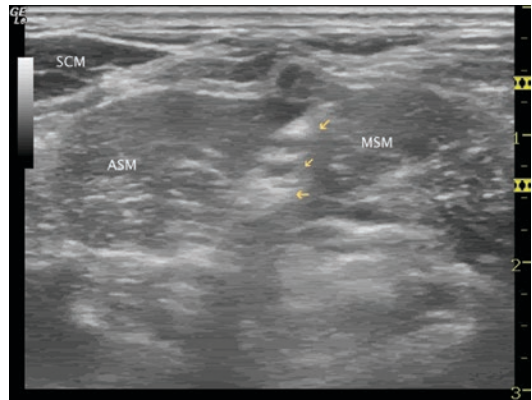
Ultrasound image of the interscalene approach to the brachial plexus showing the trunks of the plexus. Displayed are the sternocleidomastoid (*scm*), the anterior scalene muscle (*asm*), the middle scalene muscle (*msm*), and the trunks of the brachial plexus (arrows)
